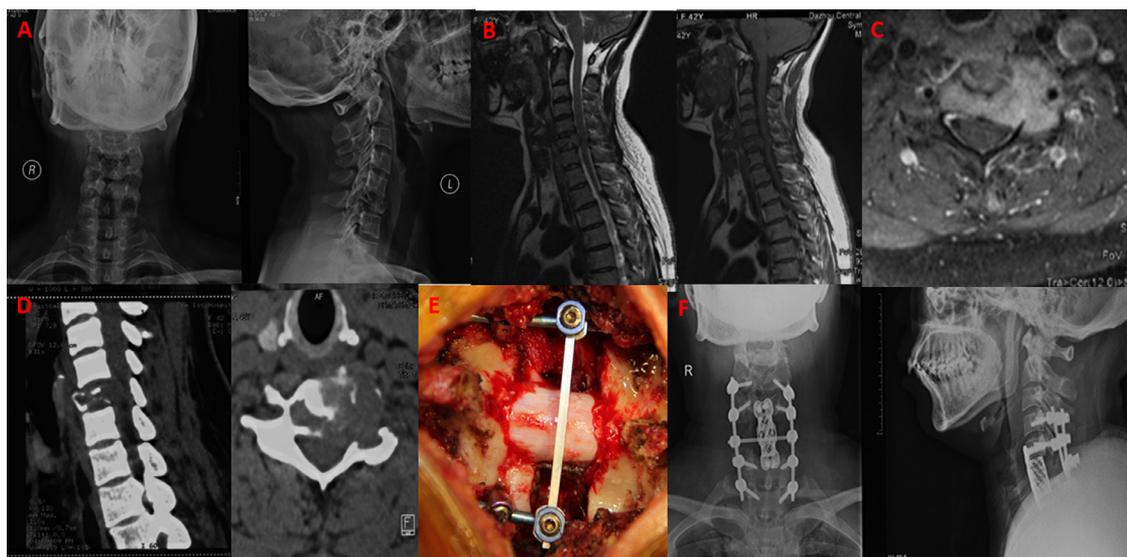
A 18-year-old girl (case 30) (A) X-ray showed the compression fracture of C6 before surgery; (B) Preoperative sagittal MRI scan (T2 and T1) showed an osteolytic lesion in vertebral body of C6; (C) Preoperative transverse section of the lesion (MRI scan) showed the WBB classification: 3-9/A-D. (D) Preoperative CT scans showed the osteolytic fracture; (E) Intraoperative picture showed the total spondylectomy and instrumentation; (F) Postoperative X-ray showed decompression and instrumentation.
